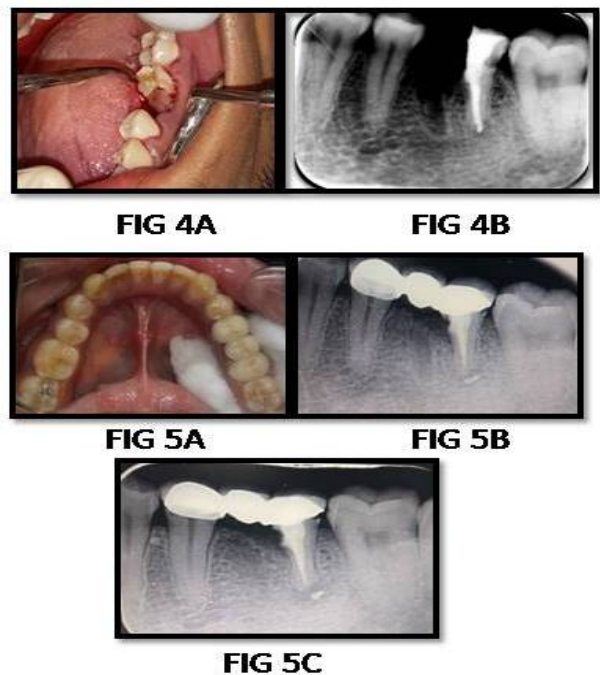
A. PRF plug and PRF membrane placement in extraction socket, B. immediate post operative radiograph.
